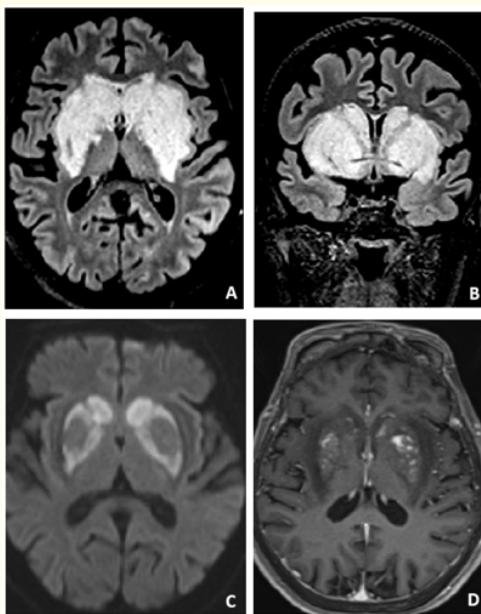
Axial (A) and coronal (B) FLAIR MRI images demonstrate bilateral symmetric hyperintensity involving the external capsule, peri-lenticular region, and globus pallidus, producing the characteristic “lentiform fork sign.” Diffusion-weighted imaging (C) shows mild hyperintensity without significant diffusion restriction, consistent with vasogenic edema. Post-contrast T1-weighted imaging (D) demonstrates mild enhancement.
